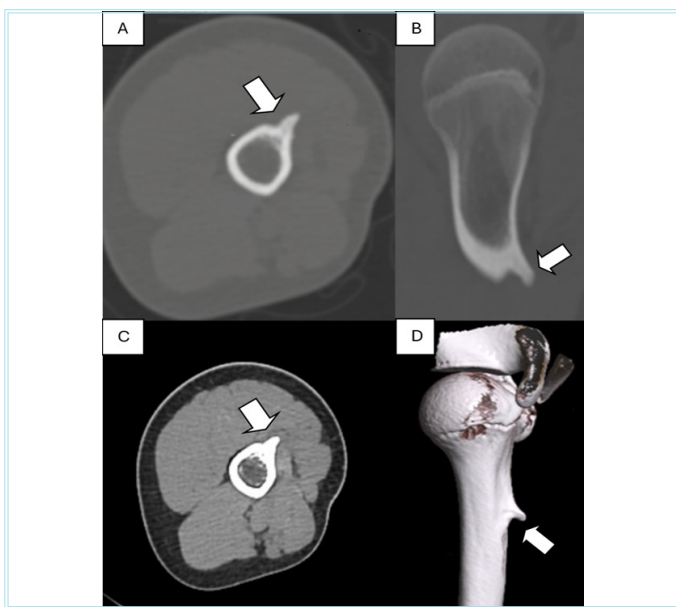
On a non-contrast computed tomography (CT) scan of the upper arm. An axial and coronal image displays a well-defined exophytic bone lesion in the bone window that lacks medullary continuity (A, B, arrow). The axial image shows no other pathology in the soft tissue adjacent to the lesion (C, arrow). We observe an exophytic bone lesion emanating from the diaphysis in the 3-dimensional-CT humerus image (D, arrow)
